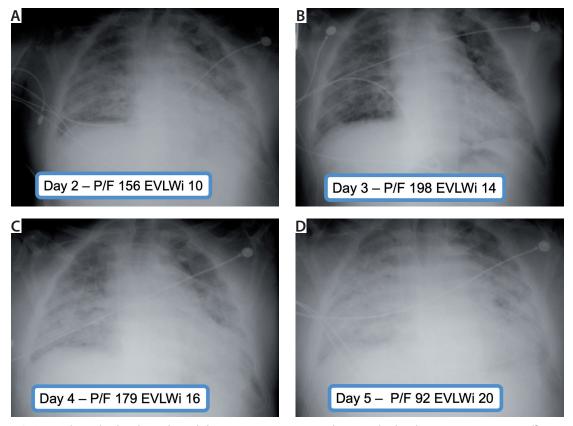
Evolution the plain chest radiograph during intensive care unit stay. The patient developed progressive respiratory insufficiency during treatment. Echocardiography showed no signs of congestion, compatible with acute respiratory distress syndrome (ARDS). Primary abdominal compartment syndrome is often associated with secondary ARDS
